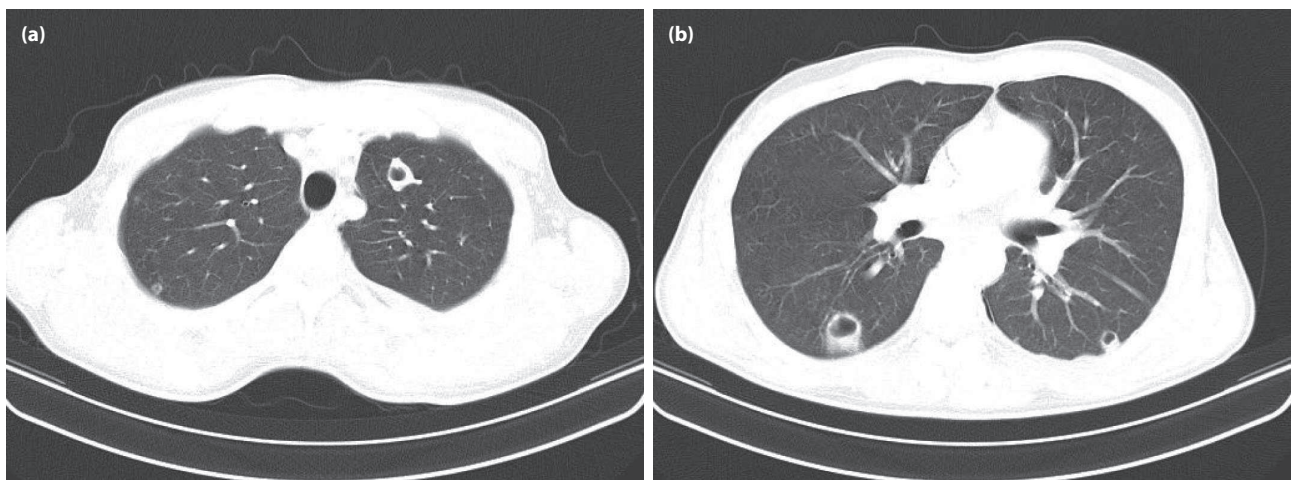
Chest computed tomography (CT) demonstrated the peripheral and bilateral nature of multiple pleural-based nodules (relatively well-defined margins and a variable degree of cavitation).
